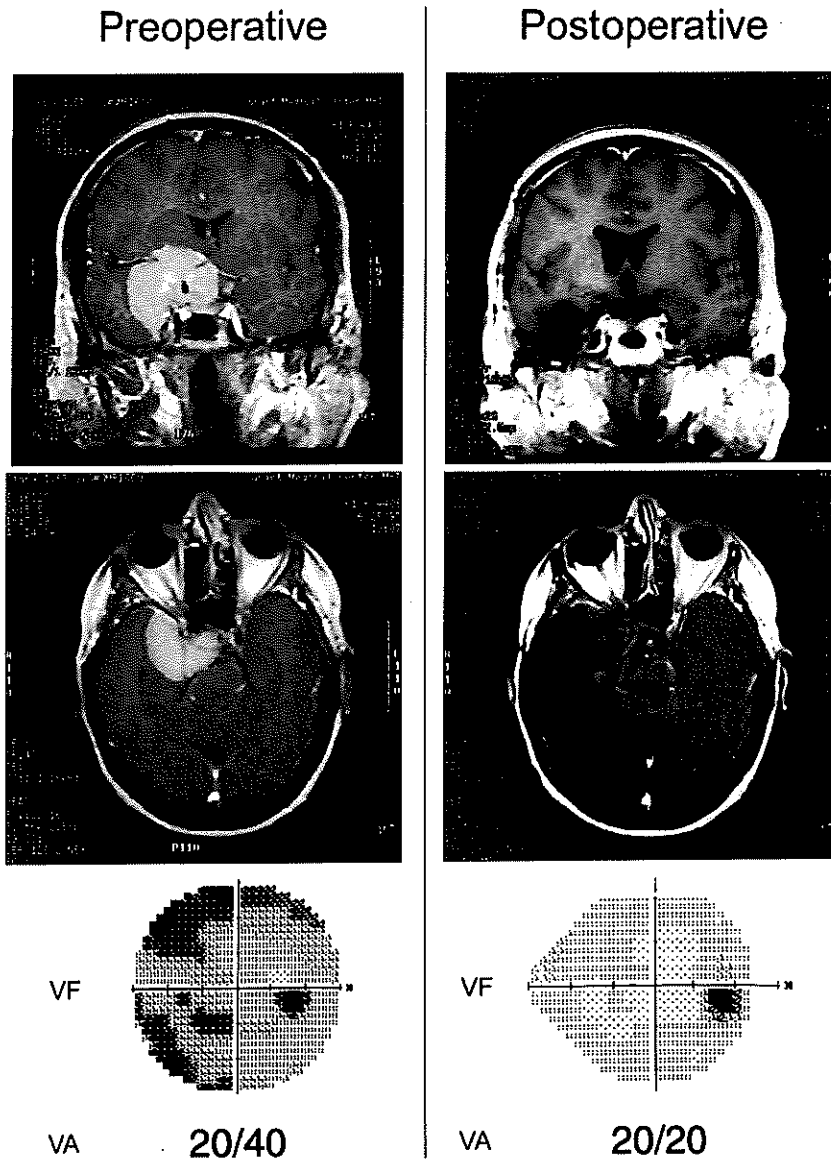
Upper and Middle Left: Preoperative coronal (upper) and axial (middle) contrast-enhanced T1-weighted magnetic resonance imaging (MRI) obtained in a 61-year-old woman. A 5-cm right clinoidal meningioma is present, encasing both the right internal carotid artery and optic nerve. Lower Left: She presented with decreased visual acuity (20/40) and visual field deficit as depicted on her Humphrey's perimetry. Upper and Middle Right: Postoperative contrast-enhanced MRI reveals complete resection of the tumor. Lower Right: Her visual acuity returned to 20/20 and her preoperative visual field deficit completely resolved.
